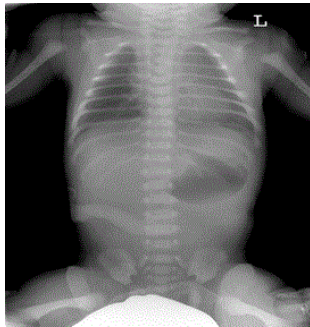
Chest X-ray, showing no pulmonary abnormality at 1 hr after birth.
